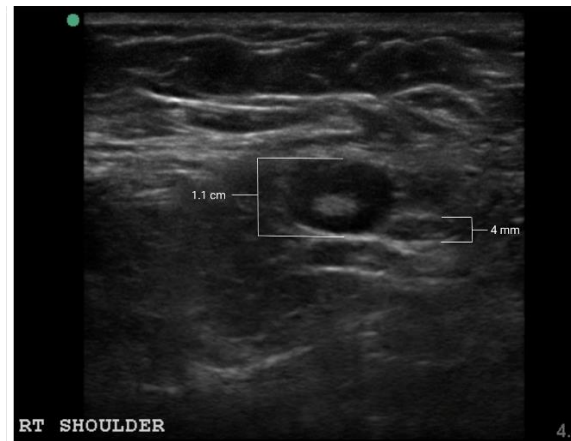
Case 1. Diagnostic ultrasound assessment of the right axillary region revealing an anechoic thickened cortex ring around the hyperechoic hilum indicating a swollen lymph node which measured 1.1 cm. Note the normal appearance of the other lymph node which measured 4 mm.
